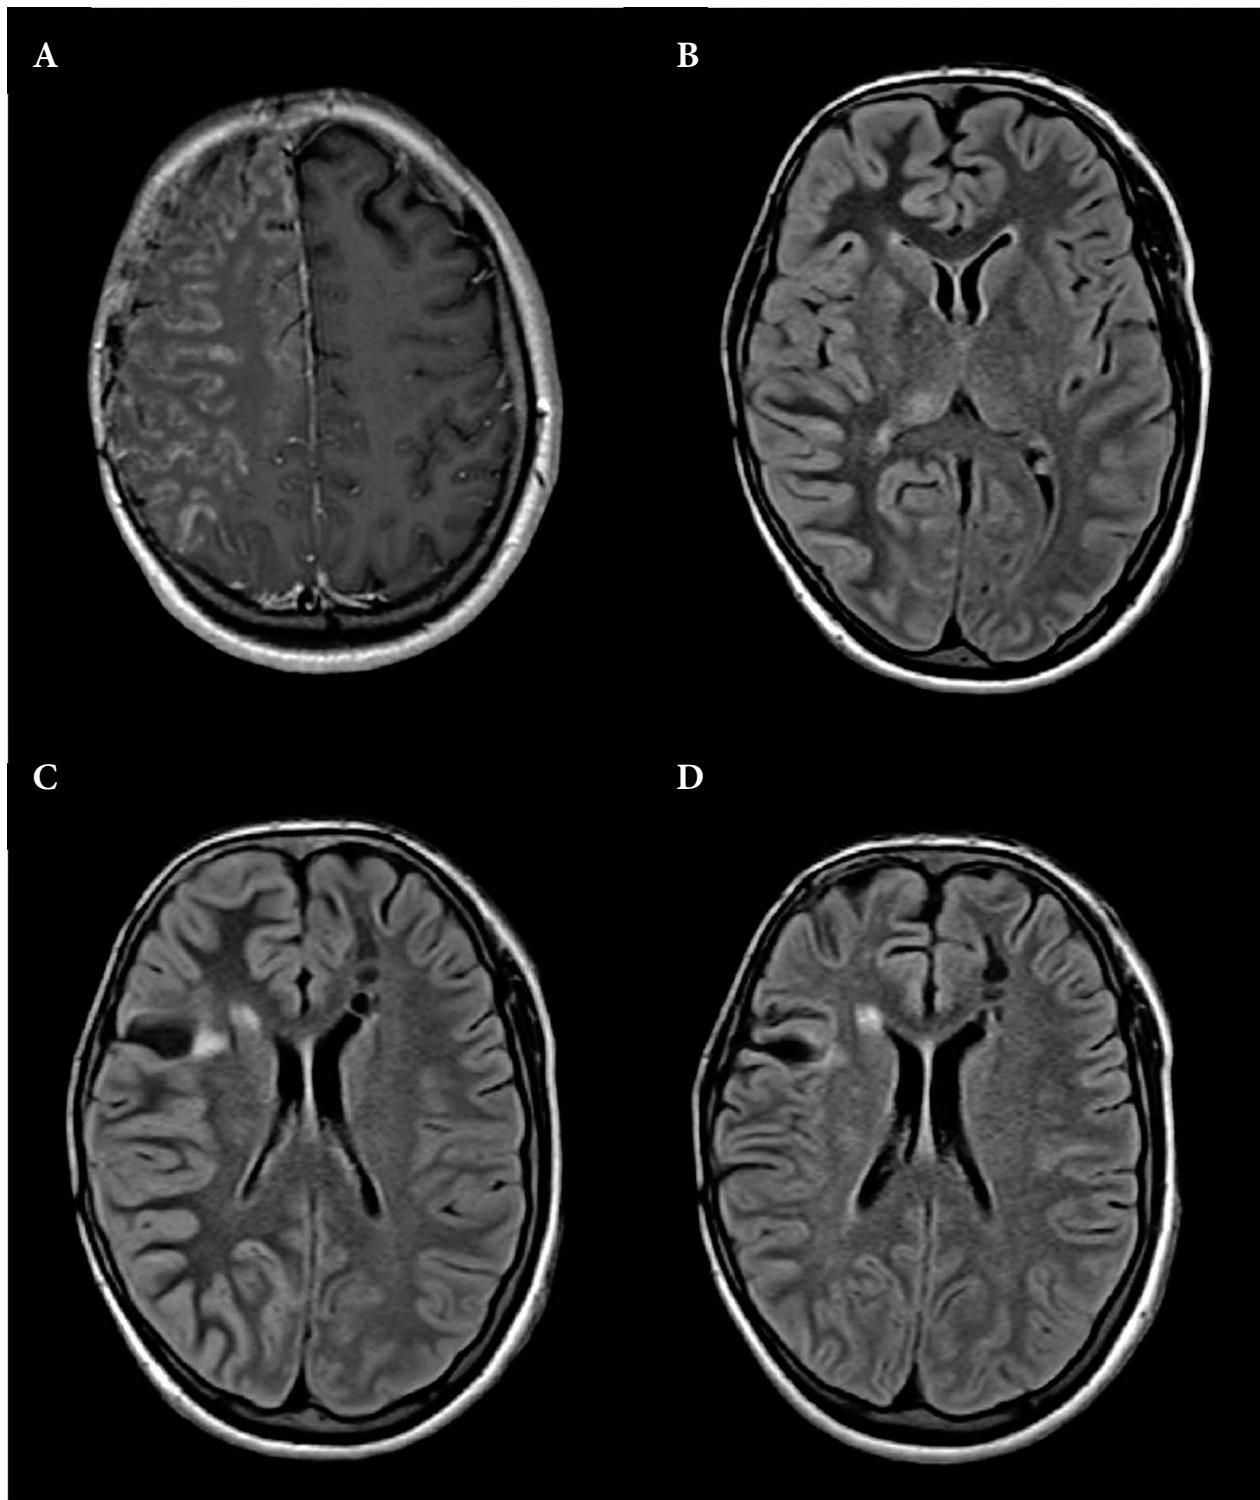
A: T1 MPRAGE contrast-enhanced sequence in the axial plane; thick gyral enhancement of the right hemisphere, sparing a part of the parietal lobe. B: FLAIR image in the axial plane through the basal ganglia with small hyperintense lesions in the right pulvinar and anterior putamen. C: FLAIR image in the axial plane through the postoperative defect in the right frontal region. Note the hypointense signal of the subcortical and partly deep white matter of the right hemisphere. D: resolution of the white matter changes on control MRI
